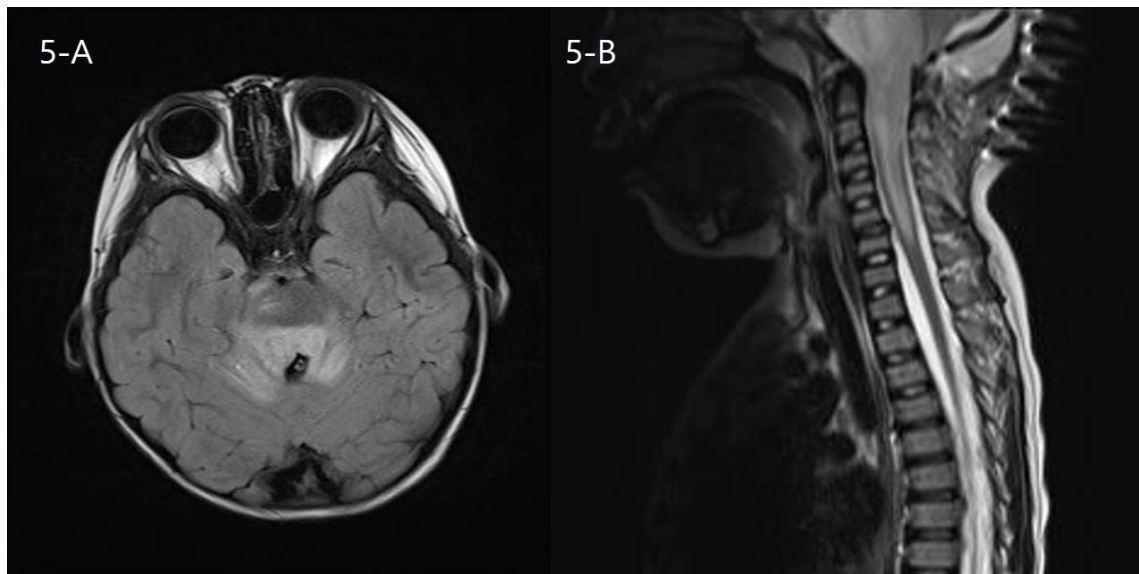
Brain and spine MRI of patient 45 diagnosed with NMOSD (Aquaporin 4 antibodies positive). The T2 high signal intensity lesion of brain stem and bilateral cerebellar peduncle is shown on T2 FLAIR (including periaqueductal and 4th ventricle area) (A). The high signal lesion from brain stem to C6 level is shown on The T2 weighted image (B). MRI, magnetic resonance imaging; NMOSD, neuromyelitis optica disorder; FLAIR, fluid-attenuated inversion recovery
